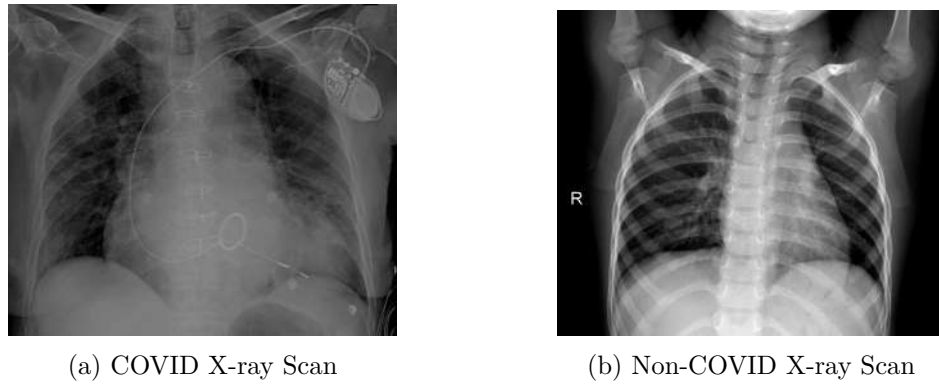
X-ray Scans of COVID IEEE-8023 Dataset
